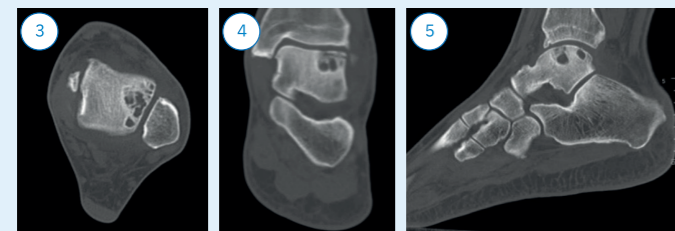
preoperative CT scans
